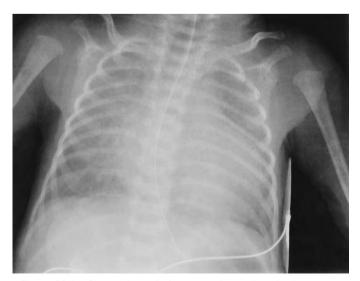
Chest radiograph showing cardiomegaly and pulmonary edema in an infant with patent ductus arteriosus (PDA).
